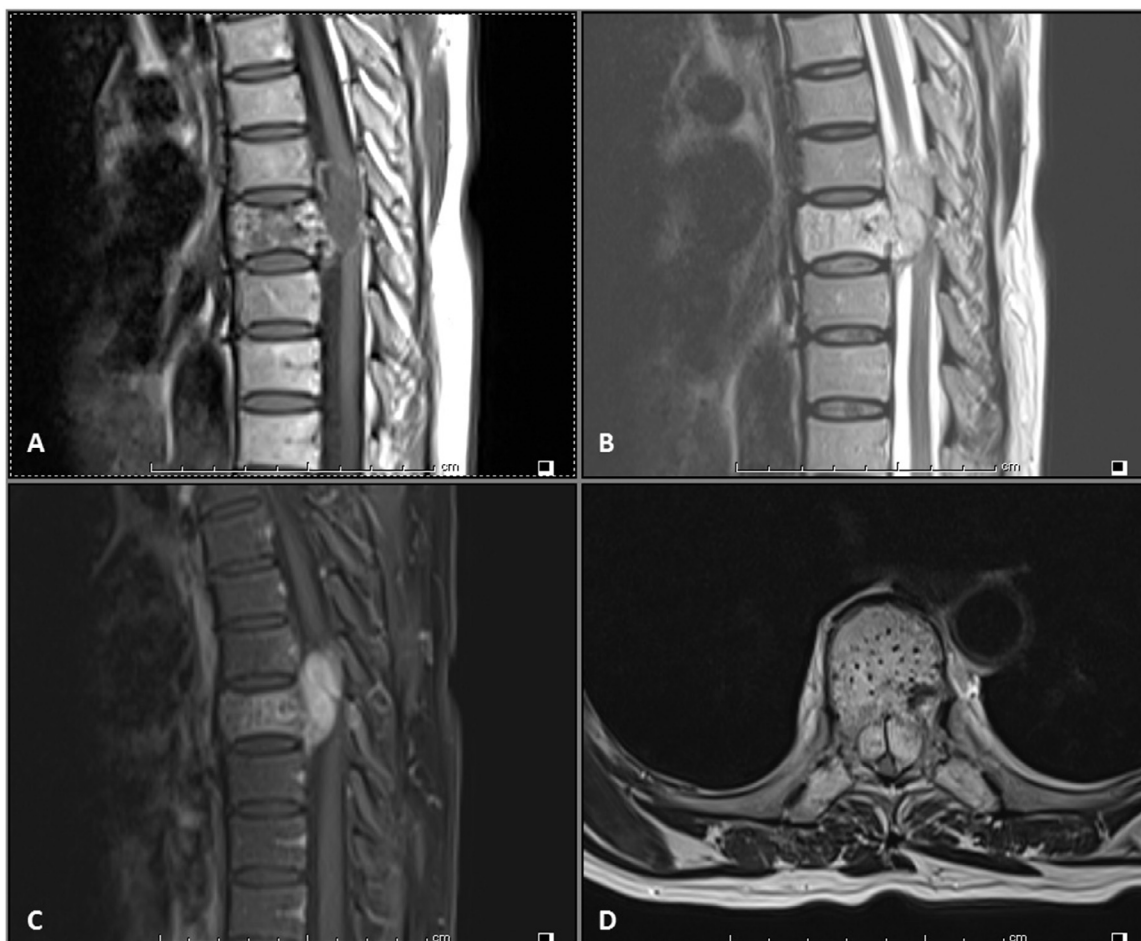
MRI of the thoracic spine: (A) Sagittal T1 sequence demonstrating a heterogeneous lesion within the T8 body and a soft tissue component in the spinal canal. (B) The lesion is noted to be hyperintense on T2-weighted sequences. (C) Enhancement with contrast is noted on gadolinium-enhanced T1 sequences. (D) Axial T2 sequence demonstrating the posterior extent of the lesion.
